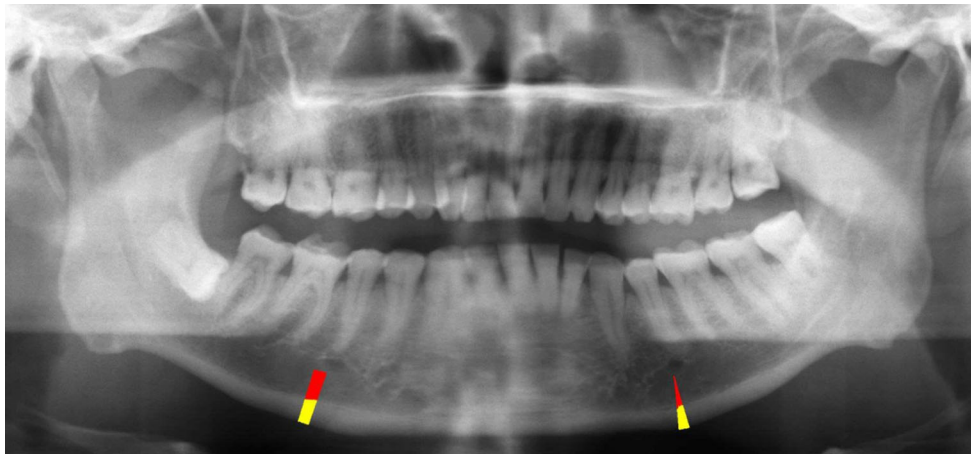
Panoramic radiograph of a 55-year-old man. MCW (yellow) was 4.5 mm on the right side and 4.2 mm on the left side. Red line, the line used to measure MCW is perpendicular to the inferior border
